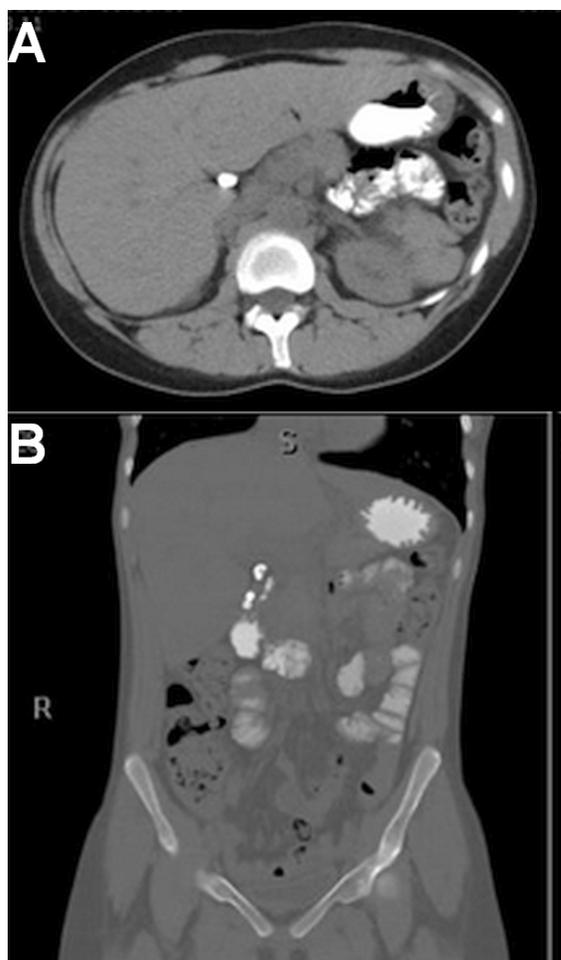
Computed tomography imaging of the abdomen with oral contrast, but without intravenous contrast. (A) The transverse and (B) coronal sections show an intrauterine contraceptive device just inferior to the liver and outside the uterus.
